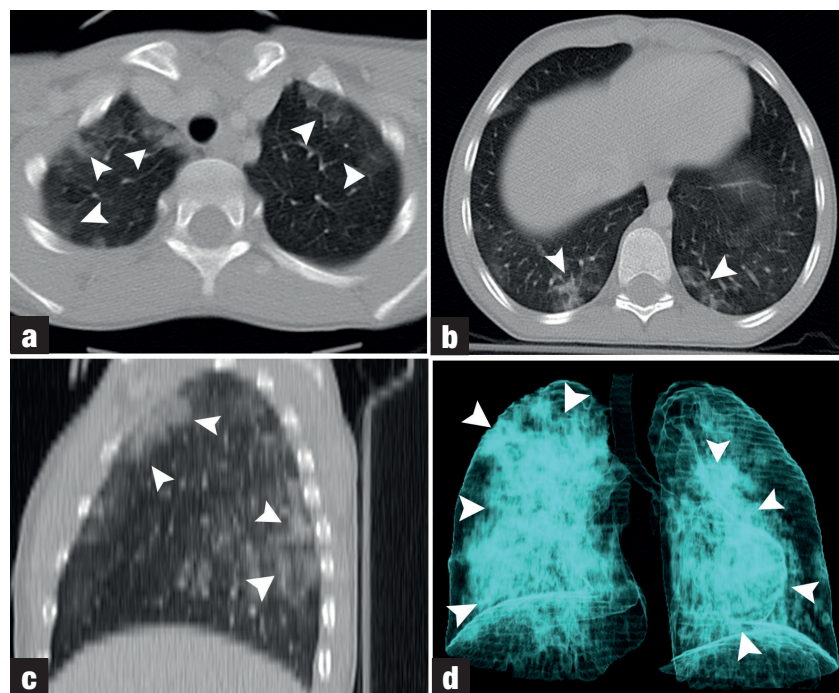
a, b, Axial, (c) sagittal and (d) volume-rendered three-dimensional reconstruction chest computed tomography images (RadiAnt DICOM Viewer 5.5.1, Medixant, Poznan, Poland) demonstrating multiple, multilobar peripherally located lesions (arrowheads).
